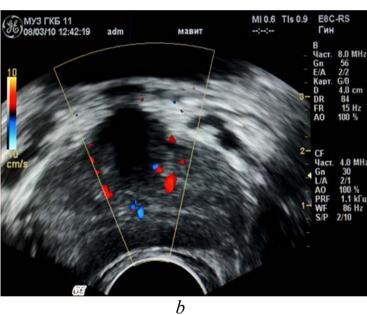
Dopplerogram of the prostate before (a) and after (b) the session of physiotherapy on the device MAVIT.
